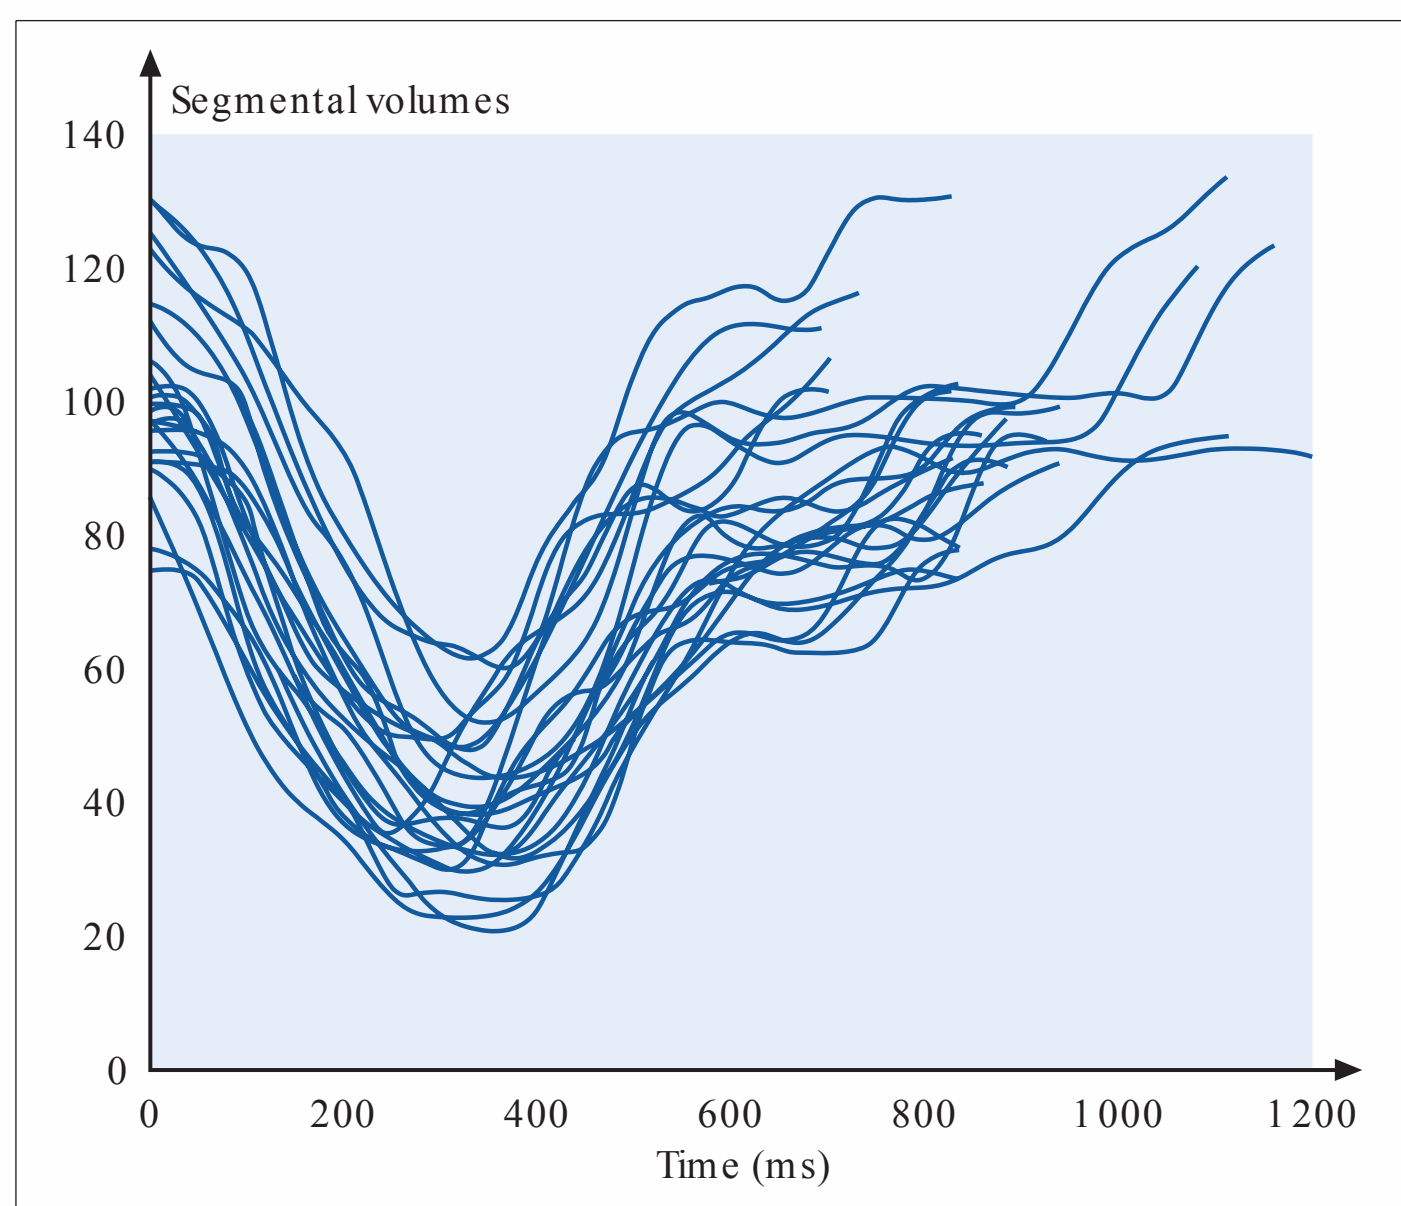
Real-time 3D echocardiography. Segmental volume–time curves.
